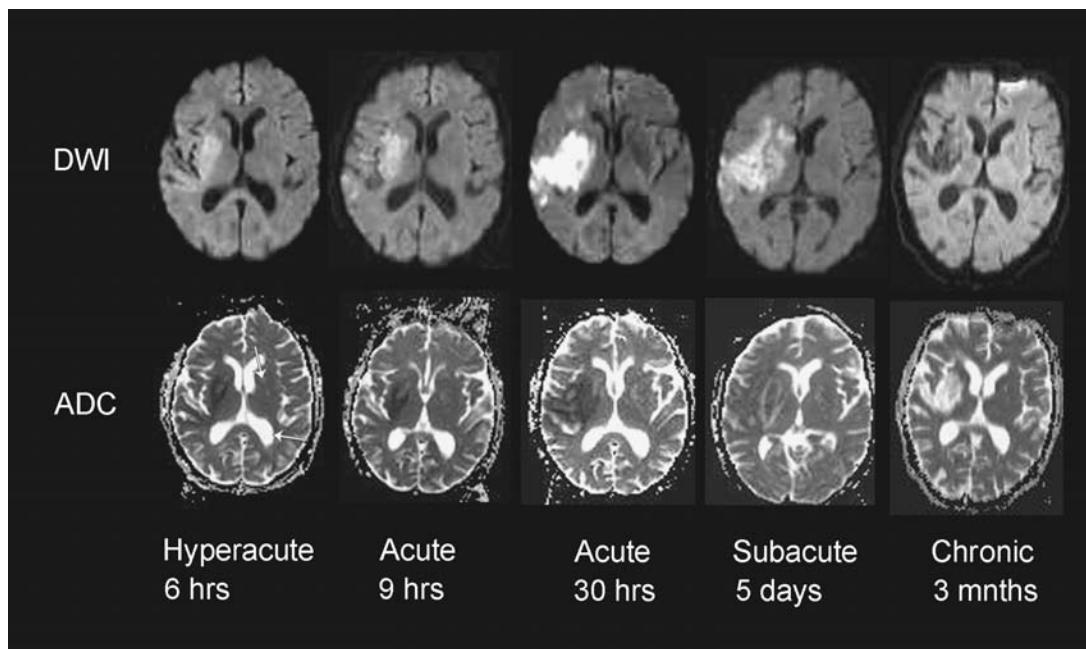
DWI and ADC time course of stroke evolution. Seventy-two-year-old female with atrial fibrillation and acute left hemiparesis. At six and nine hours, the right MCA infarction is mildly hyperintense on DWI and mildly hypointense on ADC images secondary to early cytotoxic edema. By 30 hours, the DWI hyperintensity and ADC hypointensity are pronounced secondary to increased cytotoxic edema. At five days, the infarction is mildly hypointense on ADC images because the ADC has nearly pseudonormalized, secondary to cell lysis and the development of vasogenic edema. The lesion remains markedly hyperintense on the DWI images because the T2 and diffusion components are combined. At three months, the infarction is hypointense on DWI and hyperintense on ADC images, secondary to gliosis and tissue cavitation. Abbreviations: DWI, diffusion-weighted images; ADC, apparent diffusion coefficient; MCA, middle cerebral artery.
